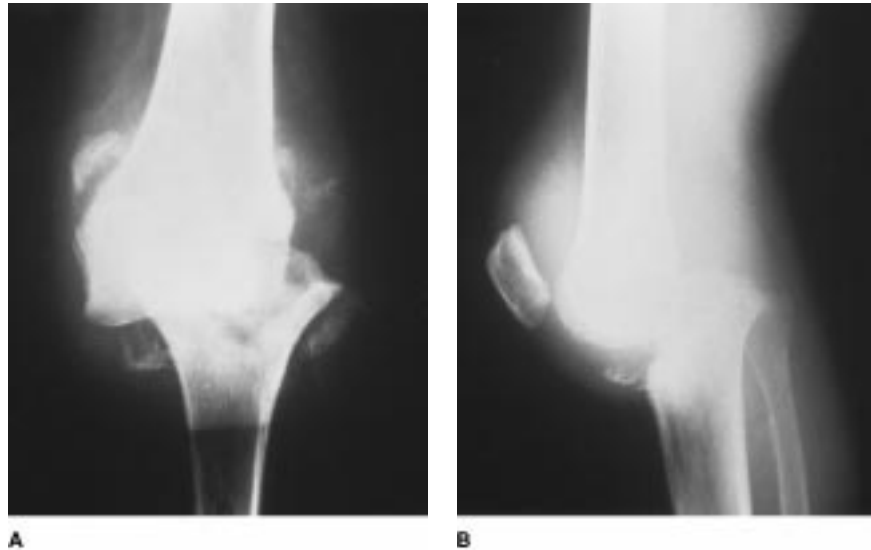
Anteroposterior (A) and lateral (B) radiographs of the knee of a patient with tabes dorsalis demonstrate gross subluxation of the tibiofemoral joint as well as joint-space obliteration and periarticular calcification.
